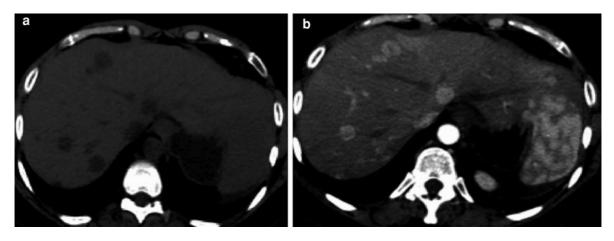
Hypervascular metastatic liver lesions from neuroendocrine tumor of the pancreas. a Transverse unenhanced CT image demonstrates two subtle low attenuation lesions in the right liver lobe. b Corresponding contrast-enhanced CT image
